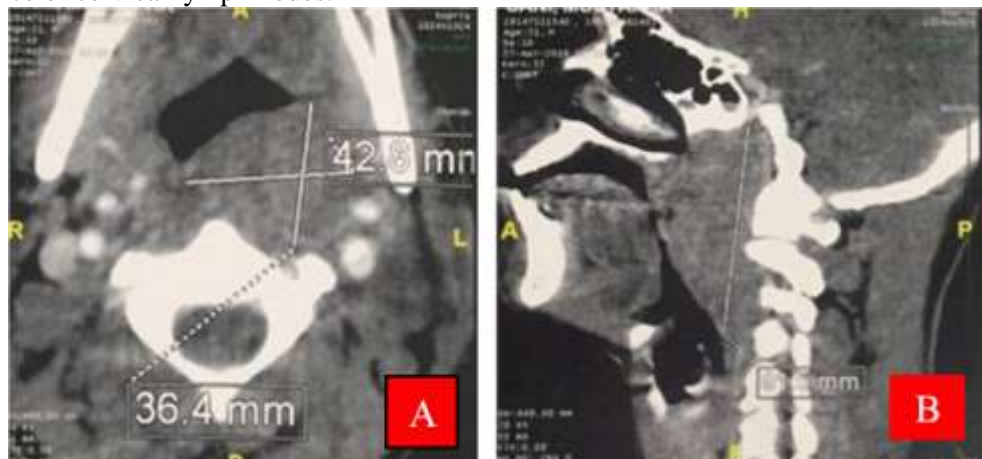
Laryngo pharyngeal CT objectifying a huge tumoral process of the soft part of pharynx in left postero lateral side measuring 48mm x 68mm x 91mm; (A: axial; B: sagittal).
